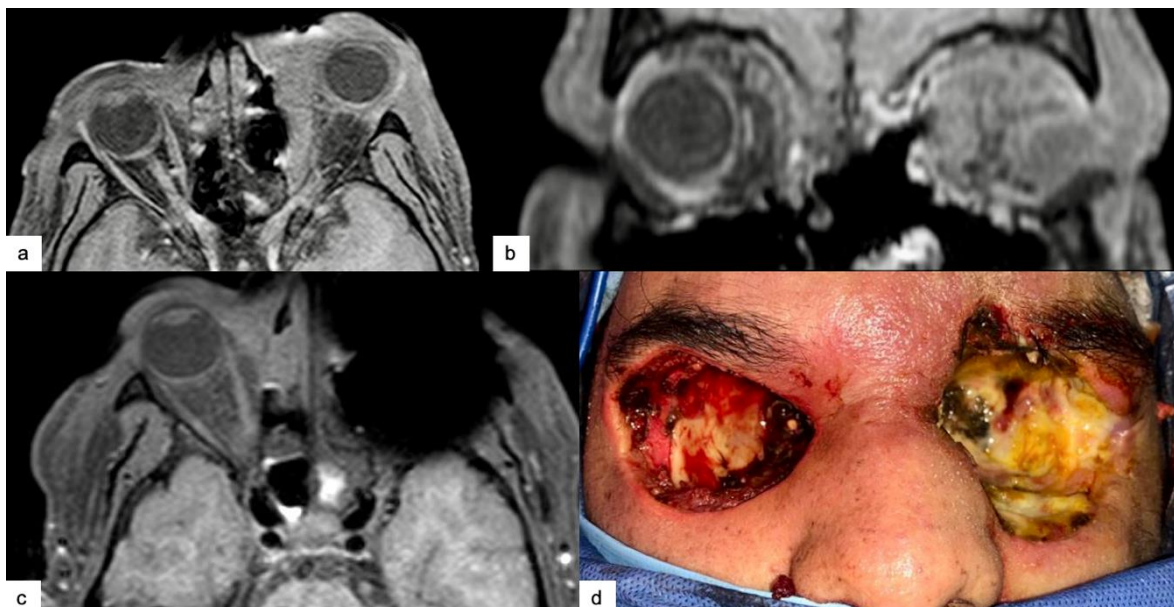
(a,b) Orbita MRI revealed orbital cellulitis predominantly left-sided. (c) Orbita MRI showed left globe exenteration and right orbit showed proptosis, extraocular muscle inflammation. (d) bilateral exenteration was performed.
